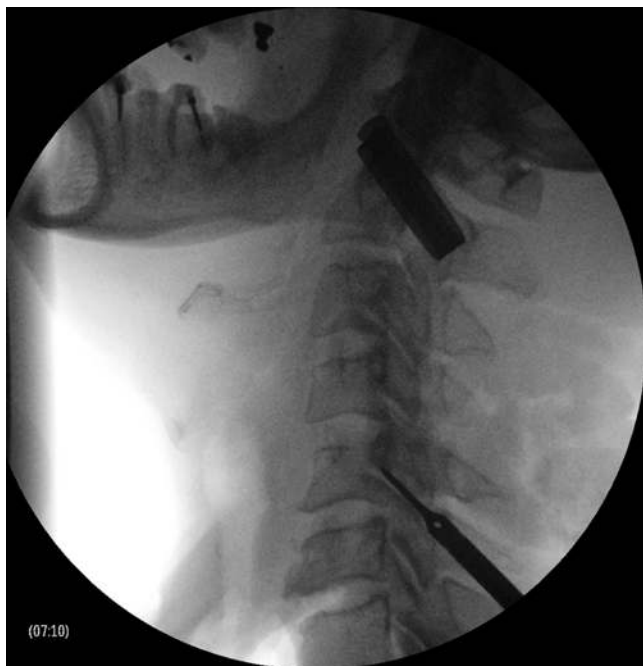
Intraoperative radiograph showing chisel abutting the pedicle of the rostral vertebra.
